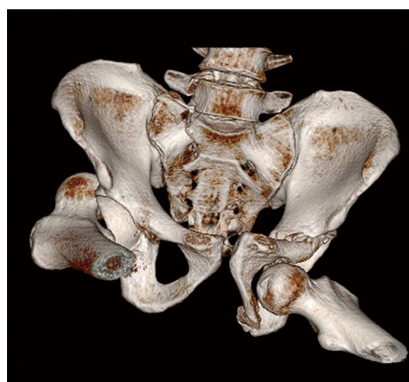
Computed tomography with 3-D reconstruction imaging showing a longitudinal sacral fracture in zone II and detachment of the symphysis pubis along with a displaced fracture of the superior pubis ramus on the left side.
